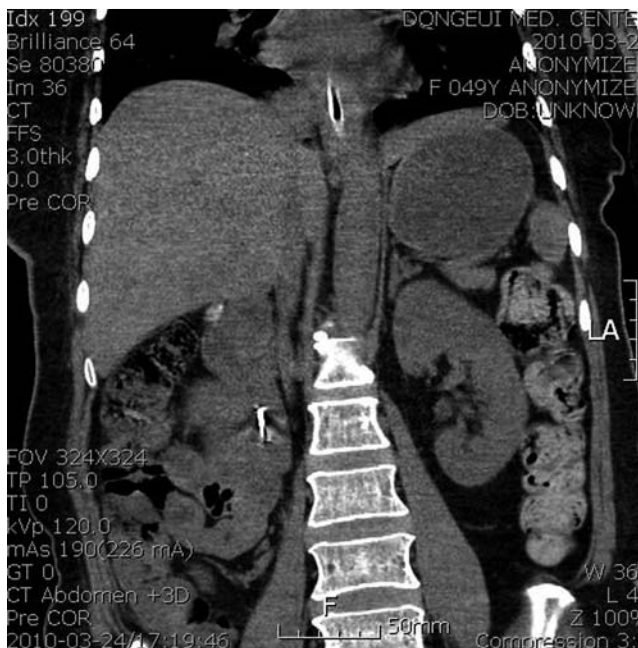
An abdominal computed tomography (CT) scan confirmed the location of the foreign body in the second part of the duodenum.
